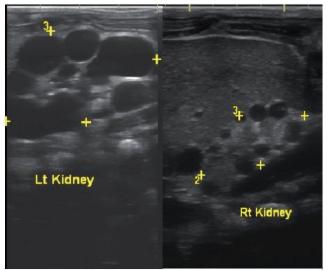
Result of kidney ultrasonography in 14 days old (a) Left kidney size: 5.24 x 3.3 cm (more than 95th percentile) (b) Right kidney size: 3.6 x 1.25 cm (lower than 5th percentile)
